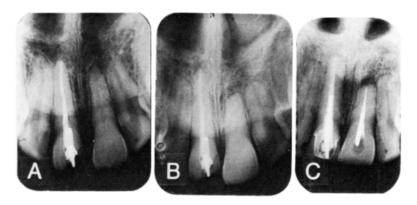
Radiographs of resorbed maxillary incisors during orthodontic treatment. A, Before treatment. B, After treatment. C, Posttreatment at 23.9 years. Note differences in resorption between endodontically treated teeth and contralateral incisor.
